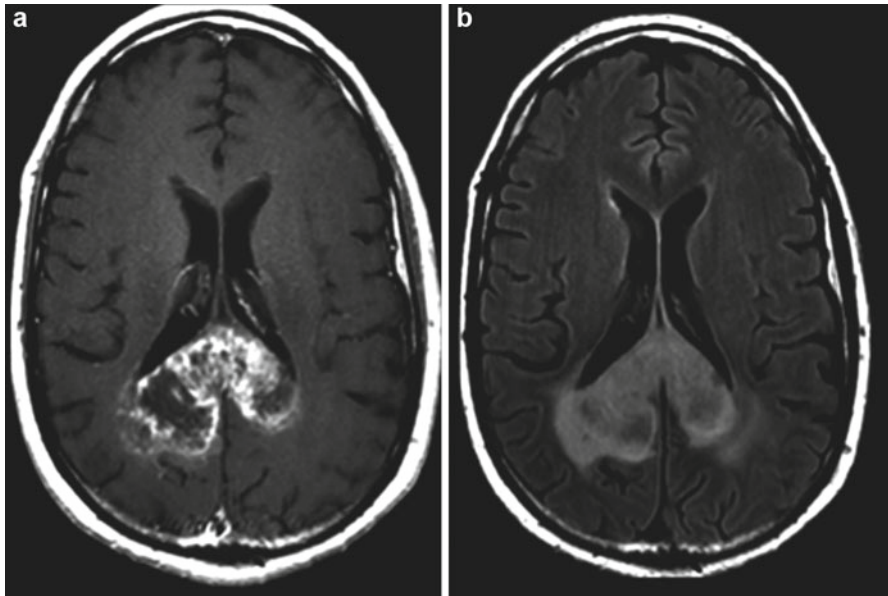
Example of a grade IV glioblastoma. (a) Post-gadolinium T1WI shows a heterogeneously enhancing mass centered on the splenium of the corpus callosum; (b) T2W FLAIR imaging of the same patient demonstrates the corresponding mass-like T2 signal abnormality; (c) MR perfusion rCBV function map clearly shows elevated rCBV within the neoplasm (*black arrow*) indicating marked tumor neovascularity; (d) post-gadolinium T1WI of a different GBM patient demonstrates secondary leptomeningeal dissemination along the septum pellucidum (*white arrow*)
